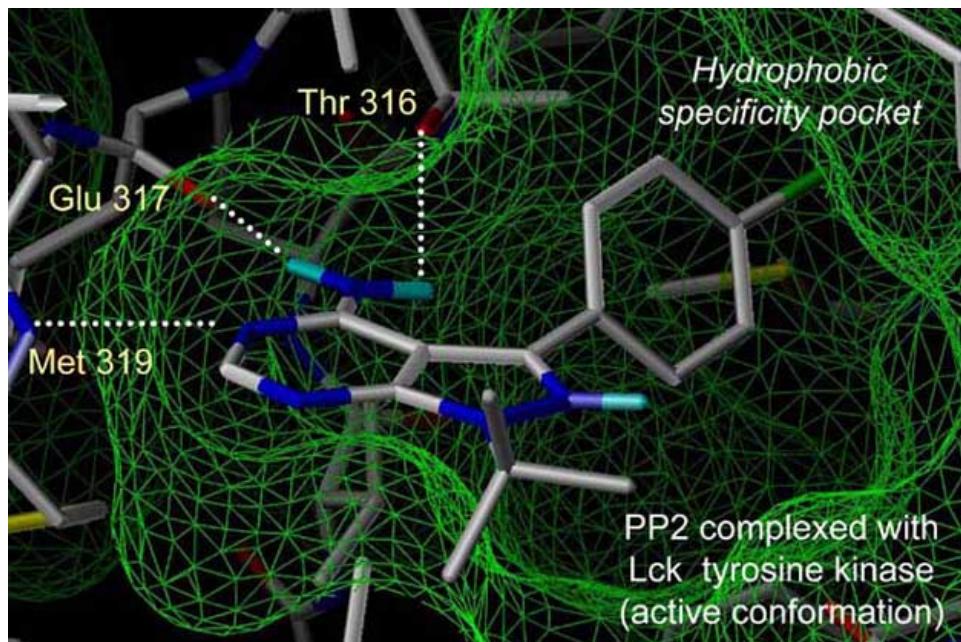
X-ray structure of Lck tyrosine kinase complexed with ATP-mimetic inhibitor PP2 in an active conformation of the protein (adapted from [189]).
